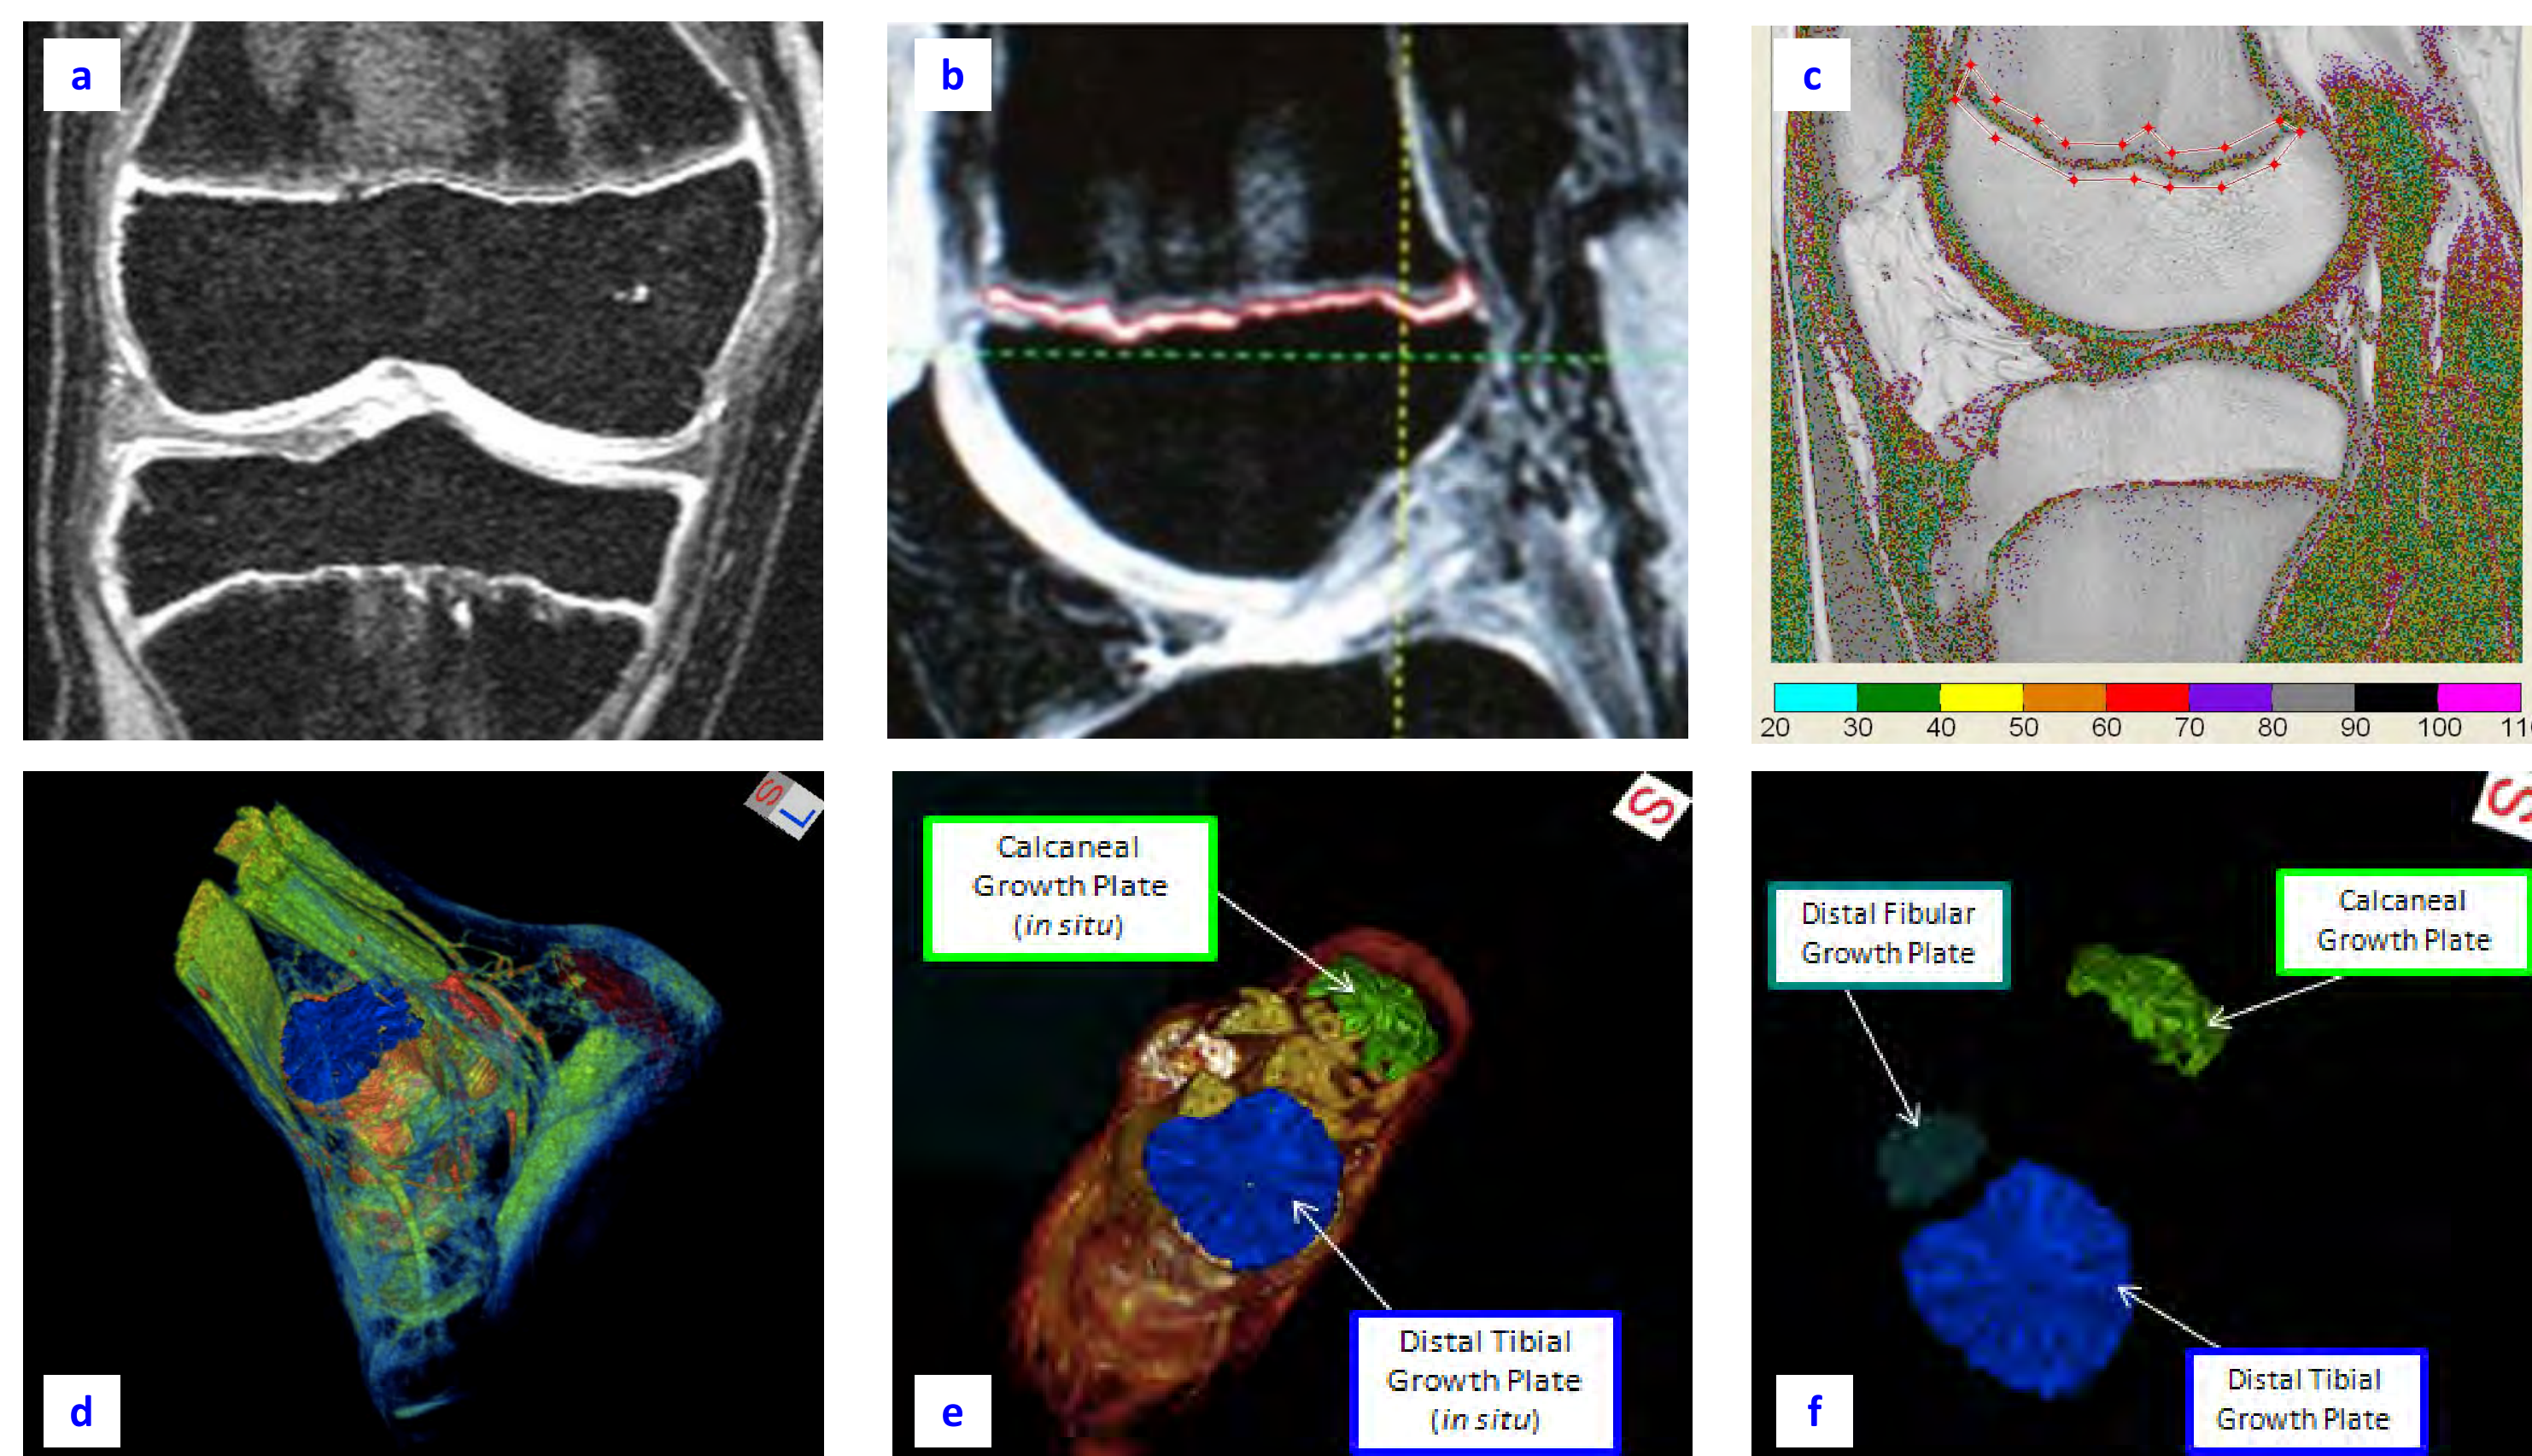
a) Coronal view of DESS MRI of the dominant right knee. b) DESS image highlighting the 'livewire' tool which enables outlining of the growth plate as seen in red. c) T2 image after extensive algorithmic programming to compute and process T2 pixels. d) to f) 3-D reconstructions of growth plates of the ankle created using OsiriX[®] software.
